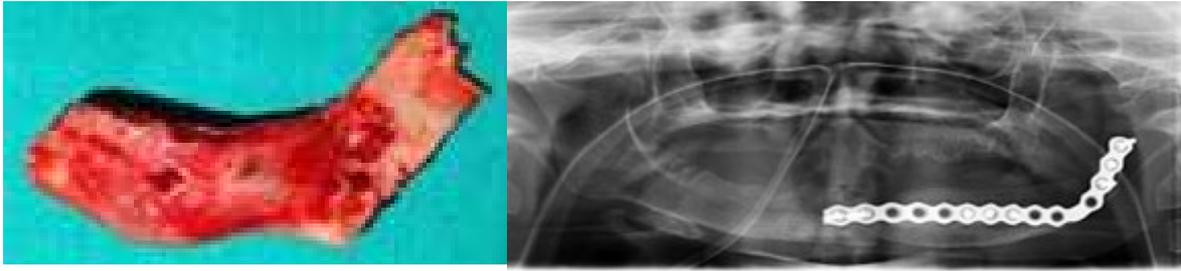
(a) and (b): Clinical and panoramic radiograph photographs showing Hemi mandibulectomy and replaced by costochondral bone graft and reconstructive plates.
